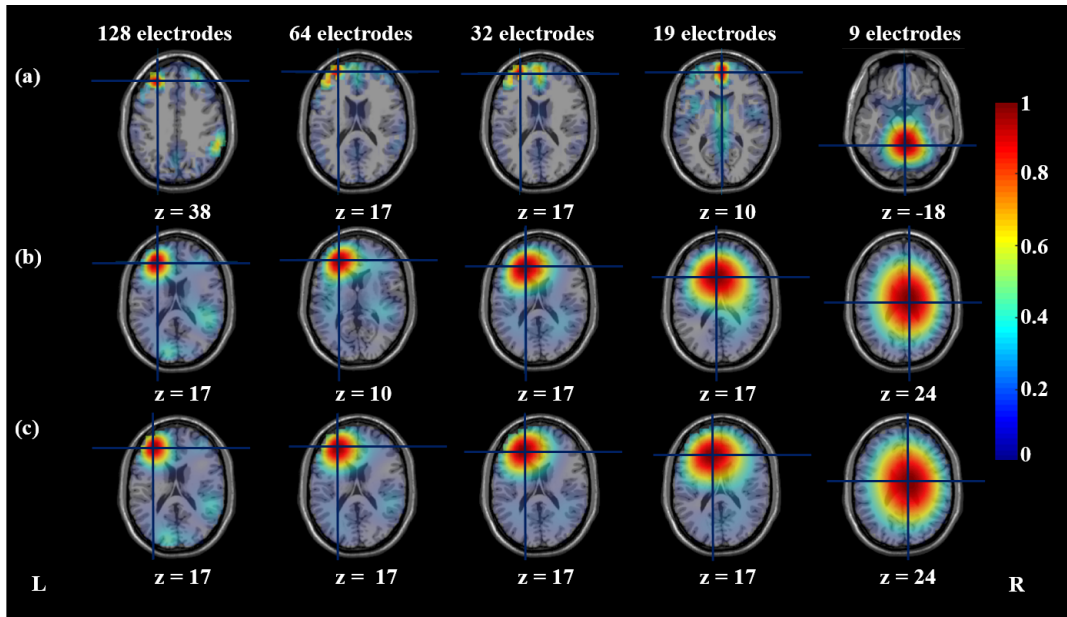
EEG source imaging results via LORETA of an averaged spike selected from the EEG dataset, which was generated from the left lateral frontal source with  $5 \text{ cm}^2$  source area. LORETA results using a gray-matter 3D grid and the classical Laplacian matrix are depicted in (a). Results using a full-brain 3D grid and the classical Laplacian matrix are shown in (b). For the results shown in (c), a full-brain grid and the modified Laplacian matrix were used. The results from the 128-, 64-, 32-, 19-, and 9-electrode datasets are shown in columns 1-5 from the left, respectively. The results are visualized as axial MRI slices at each spike's peak, and the cursor is placed at the maximum of the estimated current density. Additionally the z-coordinates of the axial slices are shown in MNI coordinates. The source imaging results were visualized using the Fieldtrip software [OFMS11]
